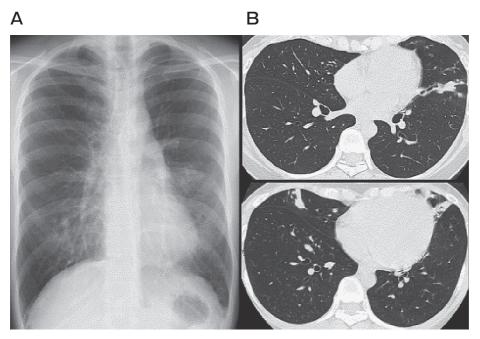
Chest X-ray and CT images: A chest X-ray showed bilateral shadows in lower lung fields (A); infiltrates and granular patterns in bilateral middle to lower lobes were observed in chest high-resolution CT (B).
